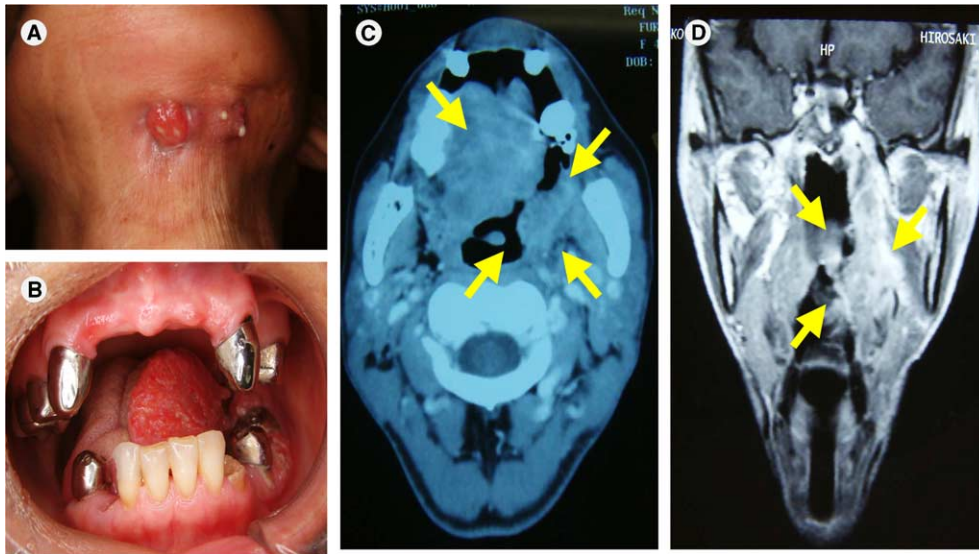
(A) Swelling at submental region. (B) Pre-treatment intra-oral photograph. (C) Pre-treatment computed tomography and magnetic resonance imaging (D). Arrows indicate the tumor invasion extent.
